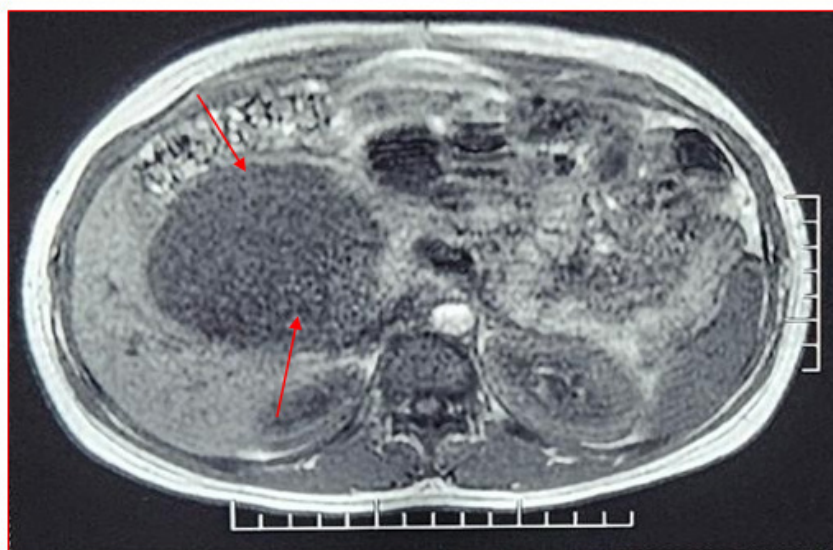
Axial contrast-enhanced upper abdominal MRI scan demonstrating a large, well-encapsulated, multiseptated tumour in the right hypochondrium (marked with red arrows), extending superiorly to periportal region.
